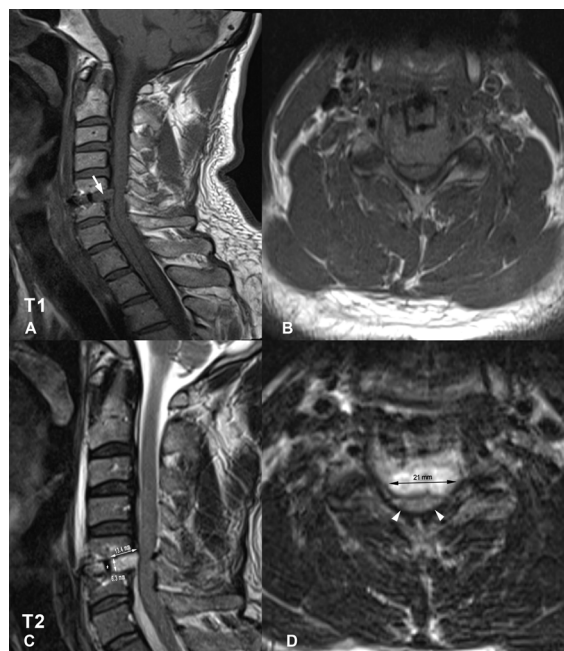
Obtained urgent MRI five hours later postoperatively. Sagittal and axial T1 and T2-weighted MR images demonstrate acute hematoma which fills the half of the discectomy cavity, compressing the dural sac and spinal cord at C5-C6 disc level. The hematoma is isointense on T1-WI and hyperintense on T2-WI (A,D arrows). Metallic cage is shown (C, asterisk). The size of the hematoma is shown in T2-weighted images (C,D).
